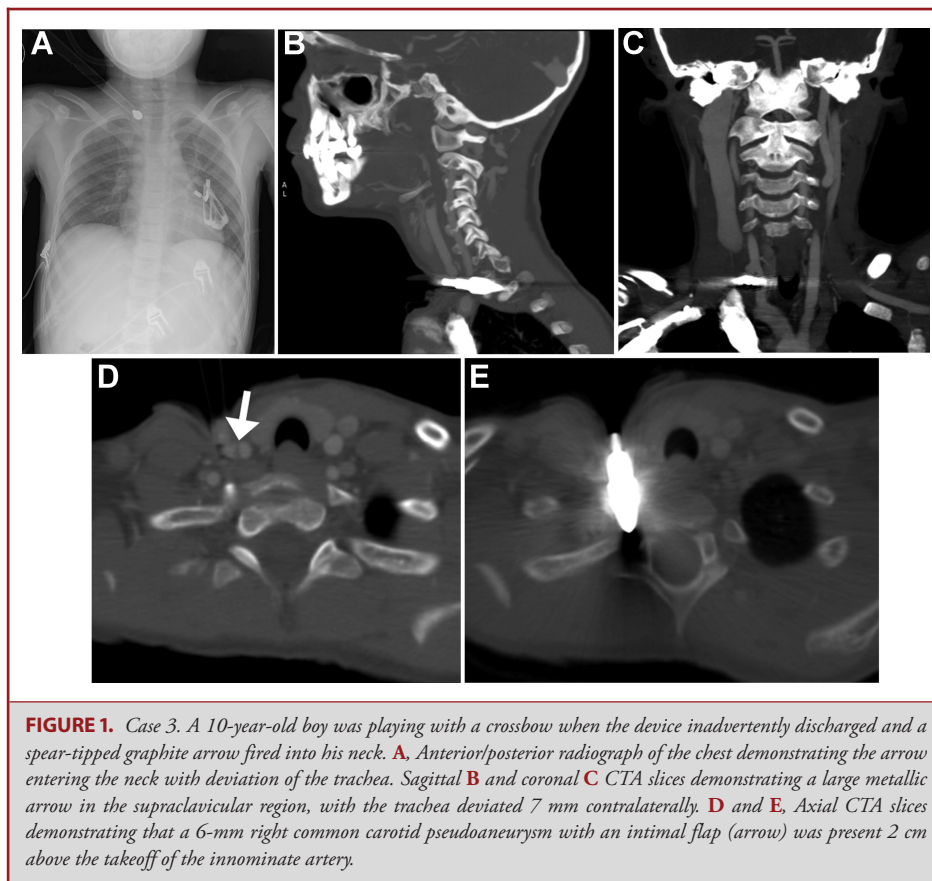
Case 3. A 10-year-old boy was playing with a crossbow when the device inadvertently discharged and a spear-tipped graphite arrow fired into his neck. A, Anterior/posterior radiograph of the chest demonstrating the arrow entering the neck with deviation of the trachea. B, Sagittal B and coronal C CTA slices demonstrating a large metallic arrow in the supraclavicular region, with the trachea deviated 7 mm contralaterally. D and E, Axial CTA slices demonstrating that a 6-mm right common carotid pseudoaneurysm with an intimal flap (arrow) was present 2 cm above the takeoff of the innominate artery.
